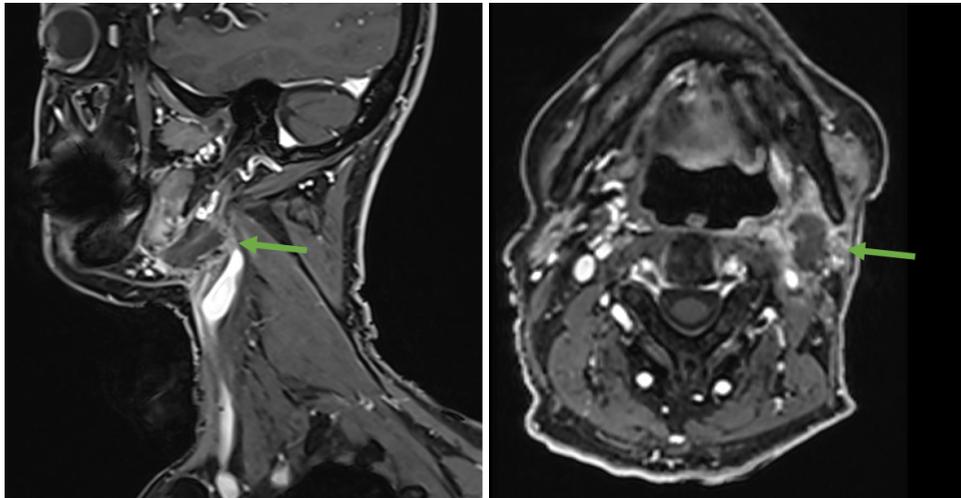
Three-month post-procedural contrast-enhanced magnetic resonance imaging: sagittal (a) and axial (b) images show an area of necrosis (30 × 20 mm; green arrow) surrounded by hyperemia, with no evidence of macroscopic locoregional residual disease.
